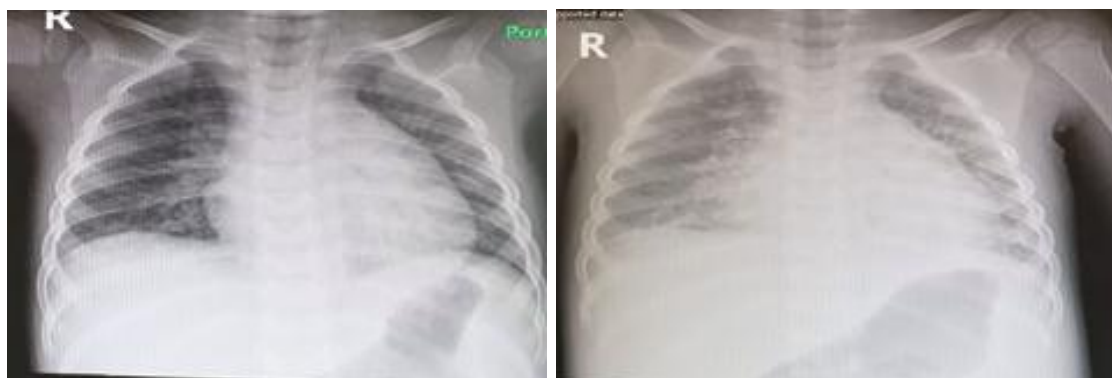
Chest X-Ray of our patient.
